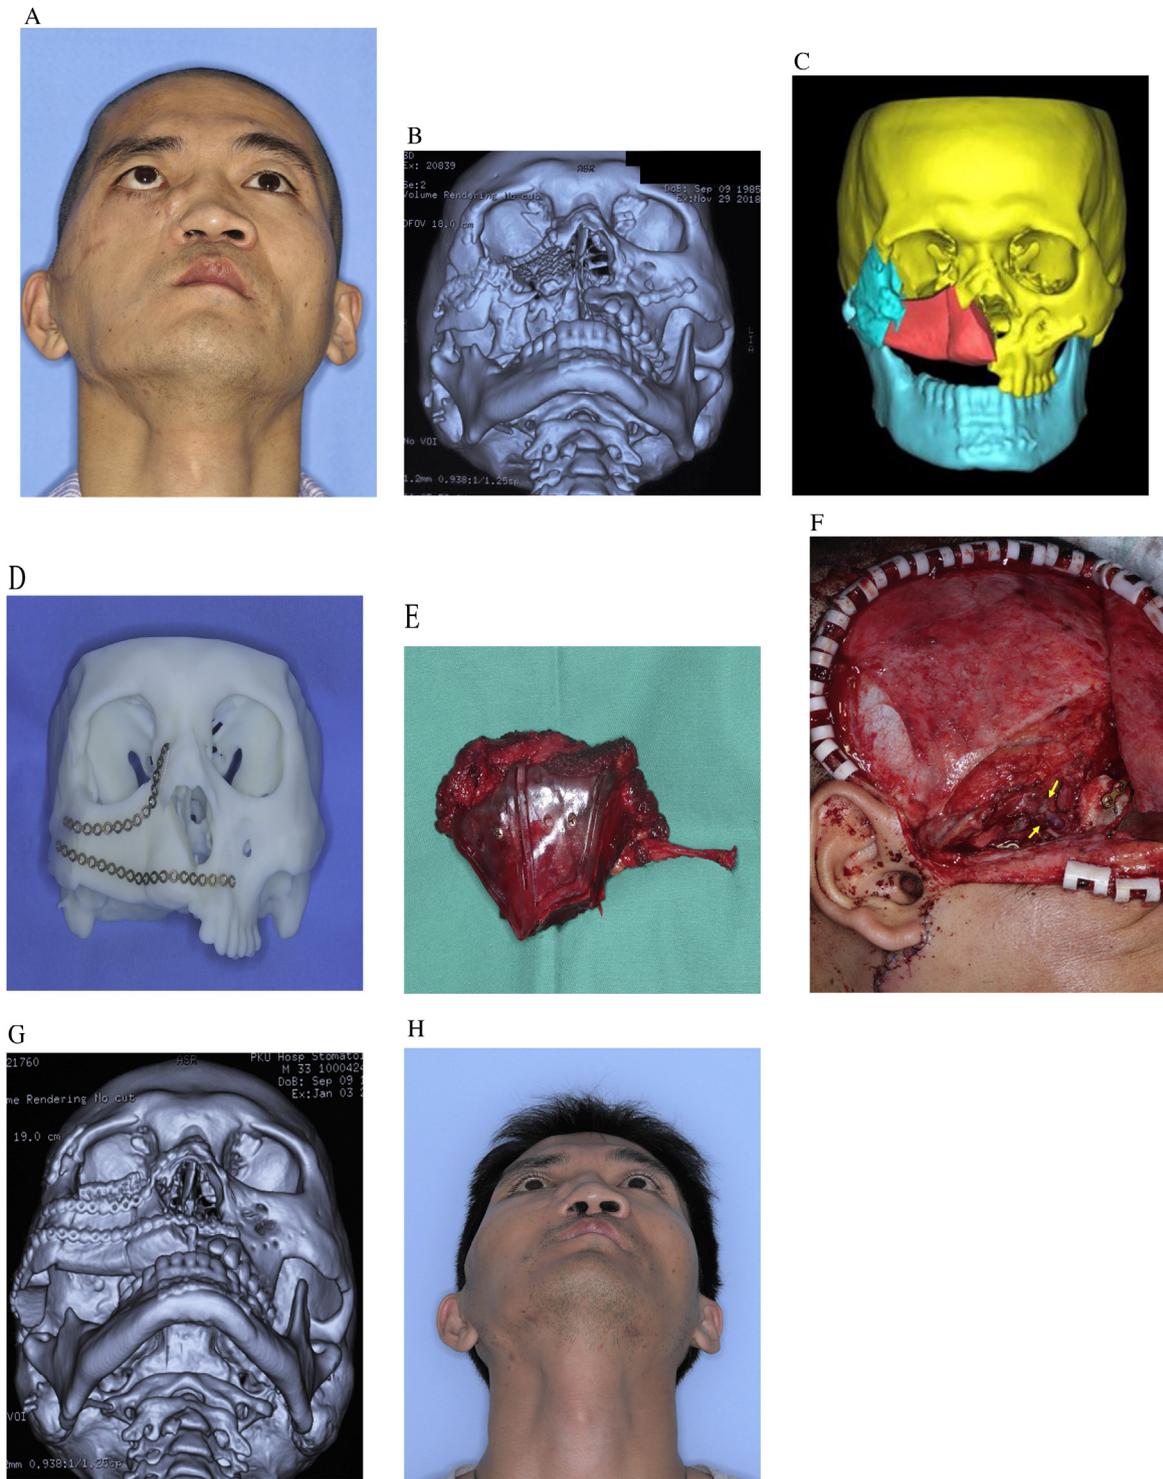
Computer-assisted reconstruction for a post-traumatic unilateral maxillary defect. Preoperative (A) photograph and (B) CT scan of the patient. (C) Virtual reconstruction with a DCIA flap. (D) Pre-bent titanium plate based on the 3D-printed skull model. (E) DCIA flap harvesting and shaping guided by the 3D-printed surgical guide plate. (F) Anastomosis between the DCIA and superficial temporal artery, and between the deep circumflex iliac vein and superficial temporal vein (arrow). The patient at 9 months postoperative: (G) CT scan, (H) photograph.
